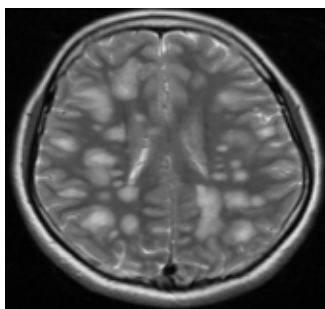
T2 weighted axial MRI (3 Tesla) sequences of brain showed multiple confluent white matter hyperintensity in both cerebral hemisphere
